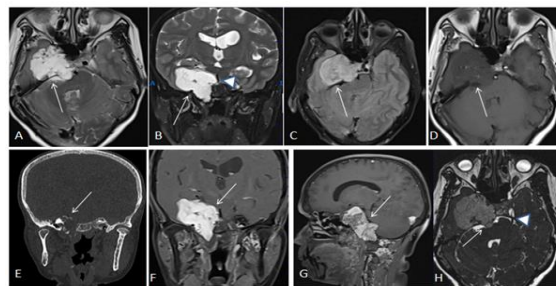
(A & C) Axial sections in T2 and FLAIR showing a well-defined heterogeneously hyperintense extra axial lesion in the base of middle cranial fossa on right side filling the Meckel's cave and extending into the right cerebellopontine angle and posterior cranial fossa on the right side (white arrows). It is seen closely abutting and displacing the brainstem towards left. (B) Coronal T2WI showing the lesion is medially abutting the right lateral aspect of clivus and the basilar artery (white arrow head). (D) The lesion shows hypointensity on T1W sequence (white arrow). (E) Coronal CT section in bone window showing expansile lytic lesion involving the right spine of sphenoid, right lateral aspect of body of sphenoid and clivus (white arrow). (F & G) Post contrast T1FS sequence in coronal and sagittal sections shows intense enhancement of the lesion (white arrows). (H) CISS sequence depicting that the cisternal segment of right trigeminal nerve is not separately made out from the lesion (white arrow). Cisternal segment of left trigeminal nerve is well made out (white arrow head). With above imaging features, DDs of trigeminal schwannoma, chordoma or petroclival meningioma were considered. HPE: Chordoma
